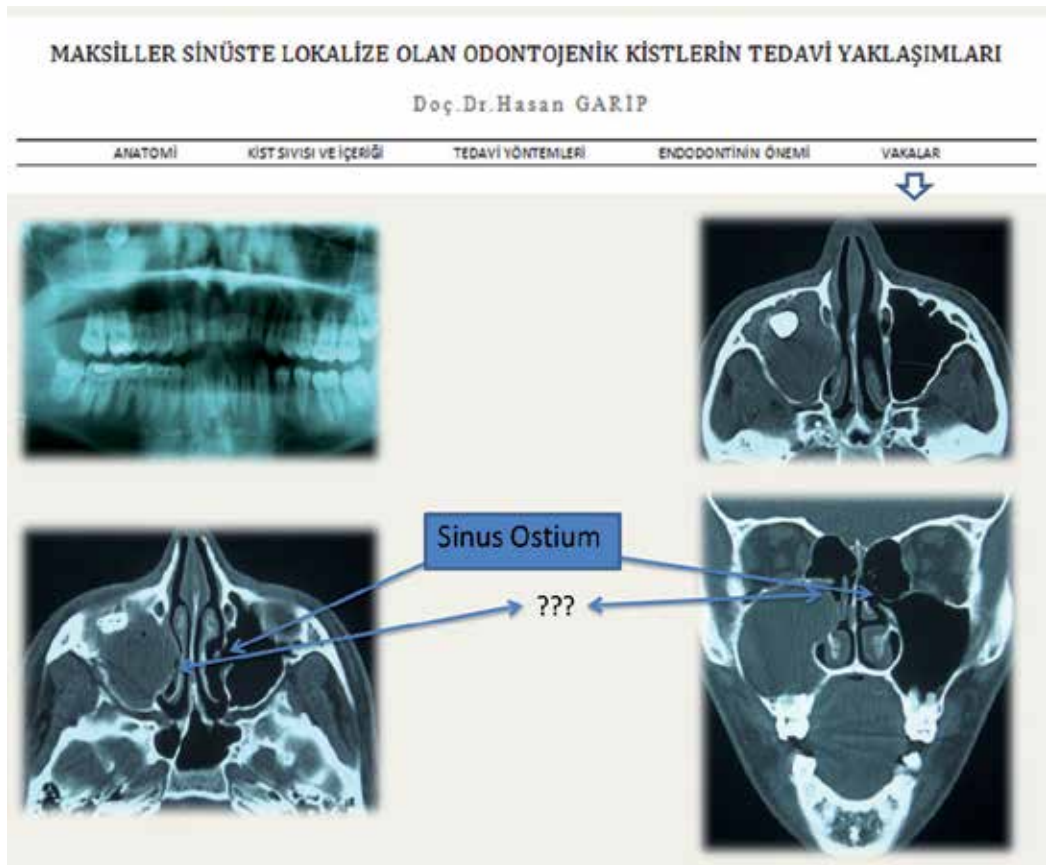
Panoramic radiograph and CT views.
